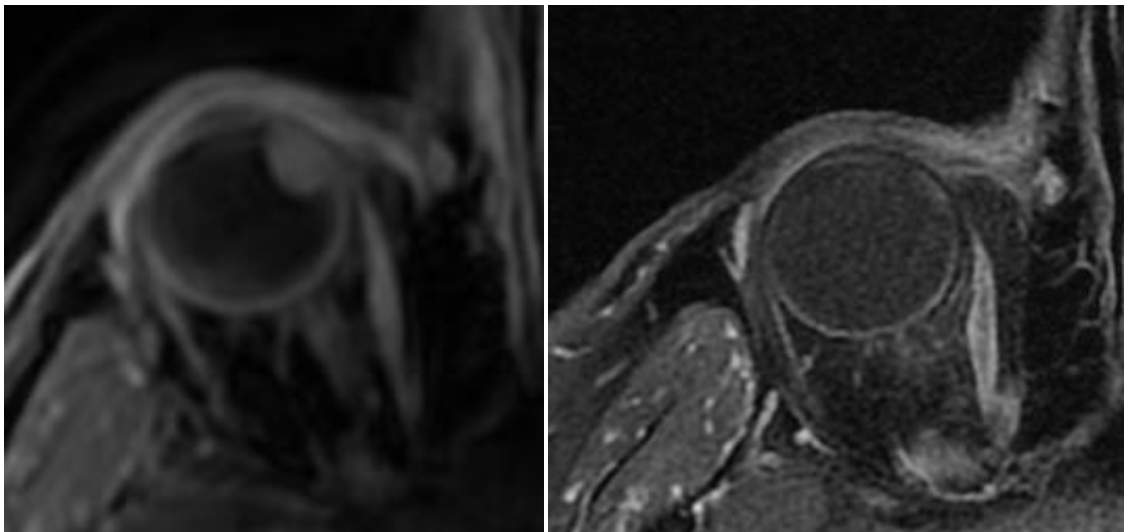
Complete Response. Axial MR imaging of patient 18th month post radiotherapy.
